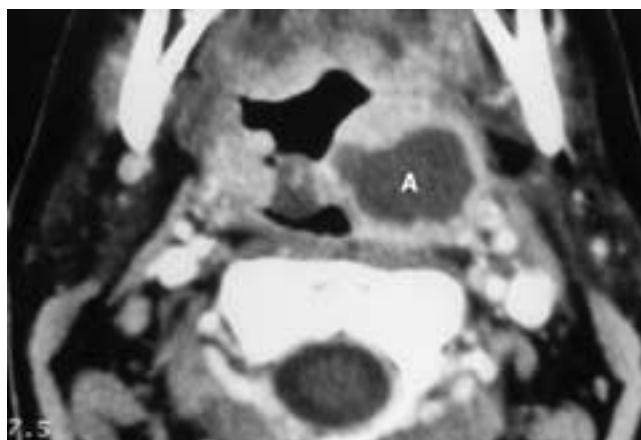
Axial contrast-enhanced CT scan shows the typical appearance of a large left tonsillar abscess (*A*).
